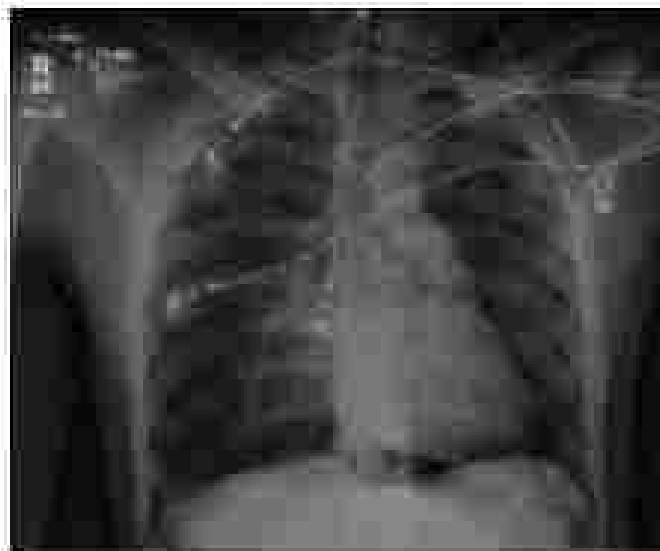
Anteroposterior chest radiograph in a patient with grade III blunt cardiac injury demonstrated a small left pulmonary contusion but did not show significant hemothorax to explain his hypotension after arrival in the emergency department.
